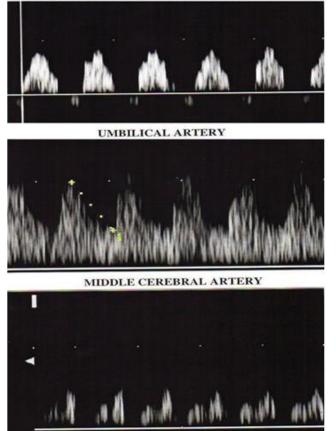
Grade 5 Doppler. Reversed Diastolic Flow in Umbilical Artery, Compensated Low Resistance Flow in the Umbilical Artery, Absent a Wave in Ductus Venosus
